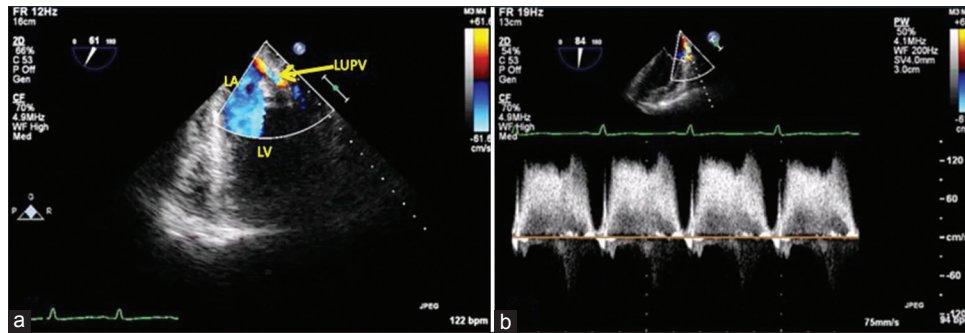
Transesophageal echocardiography-(a) mid esophageal left upper pulmonary vein view and (b) pulsed wave Doppler of left upper pulmonary vein showing dynamic obstruction with peak velocity of 1.2 m/s. LA: Left atrium, LV: Left ventricle
